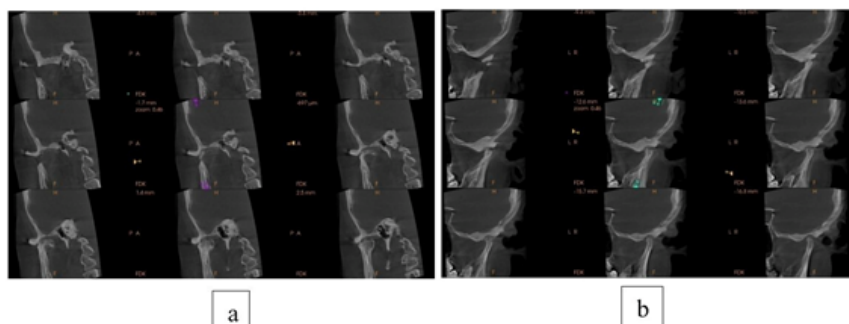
CBCT image of Left TMJ. (a) Coronal sections demonstrating joint space narrowing and intra-articular loose bodies, suggestive of advanced degenerative joint disease with possible early ankylosis on the lateral aspect of condyle
